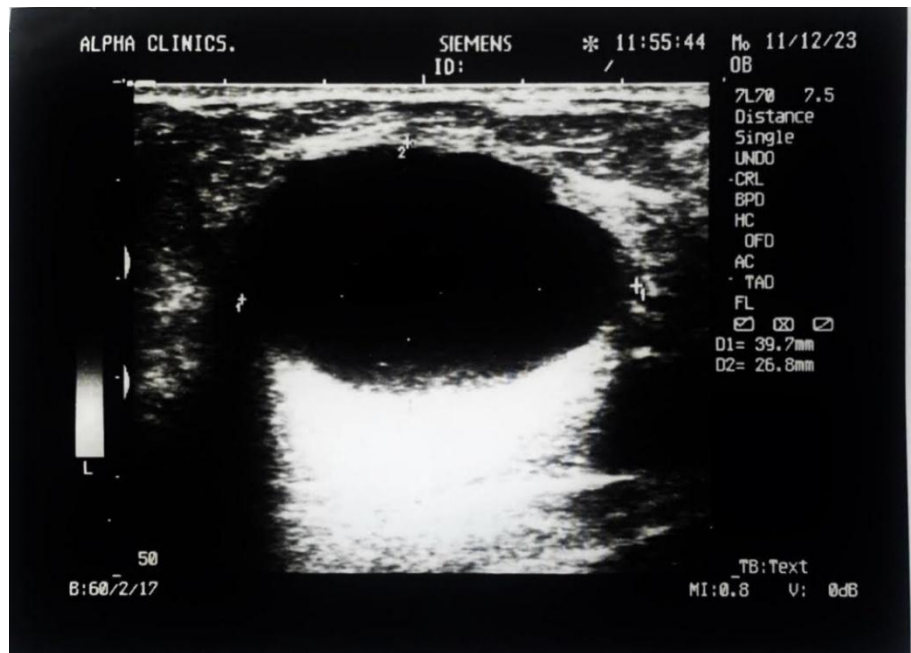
ULTRASOUND IMAGE OF THE CYSTIC BREAST MASS
